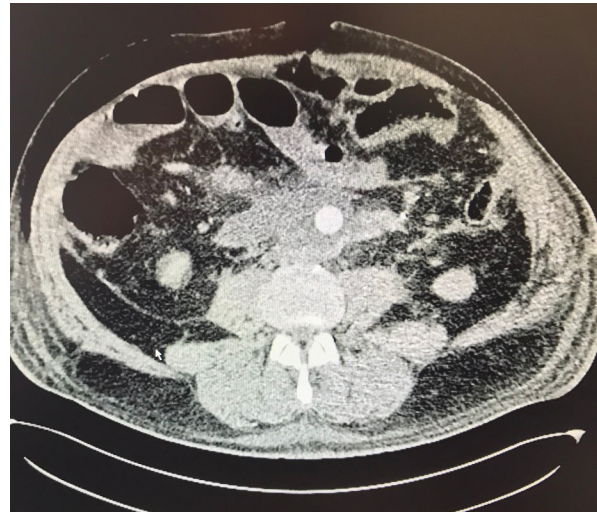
Postoperative computed tomographic angiogram (transverse view) of the infrarenal aorta shows no vascular complications.
